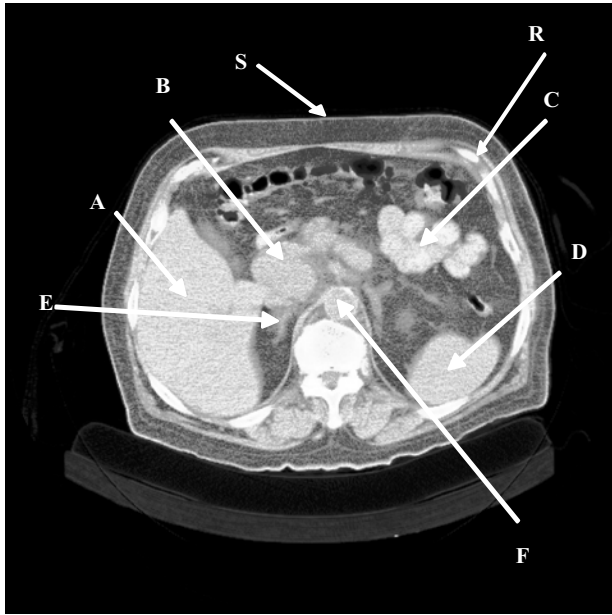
Contrast enhanced, helical CT scan through the abdomen and the head of the pancreas obtained with a reconstruction width of 8 mm (equal to slice thickness). A = liver; B = head of pancreas with tumor; C = bowel; D = spleen; E = right adrenal; F = aorta.
